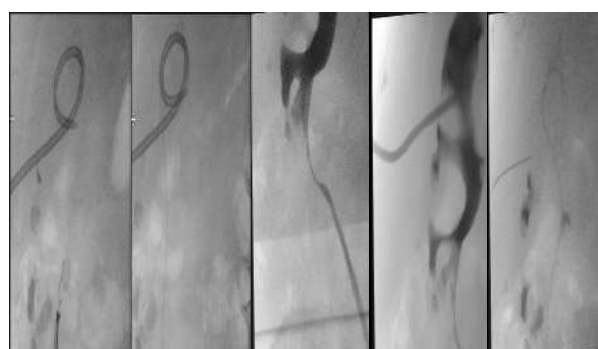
Intraoperative radiographs and retrograde ureteropyelography of case 2 in the supine position during the second stage of treatment
